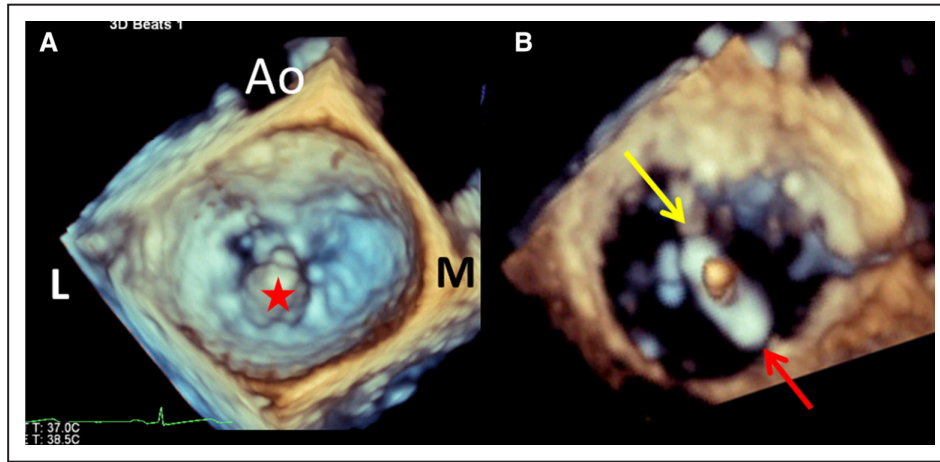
Use of three-dimensional (3D) transesophageal echocardiography (TEE) for MitraClip. A, The use of 3D from the surgical view with the aorta (Ao) at the 12 o'clock position, and lateral (L) commissure to the left, medial (M) commissure to the right. The leaflets and location of the flail P2 scallop (star) are imaged using normal gain settings. Imaging of the MitraClip (yellow arrow=anterior arm and red arrow=posterior arm) both above and below the leaflets can be achieved from the midesophageal view by reducing the gain settings (B). In this instance, the clip arms should be rotated in a clockwise direction to align perpendicular to the coaptation line.
